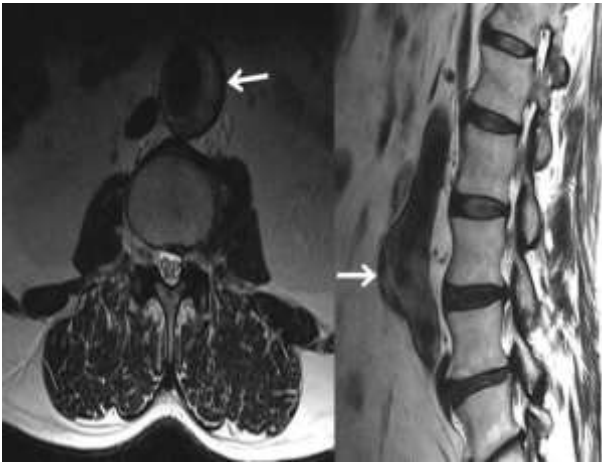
Fusiform aneurysm with T2-weighted axial sagittal MRI with a thrombus thickness of 17 mm, starting from the infrarenal level in a 70-year-old male patient.
